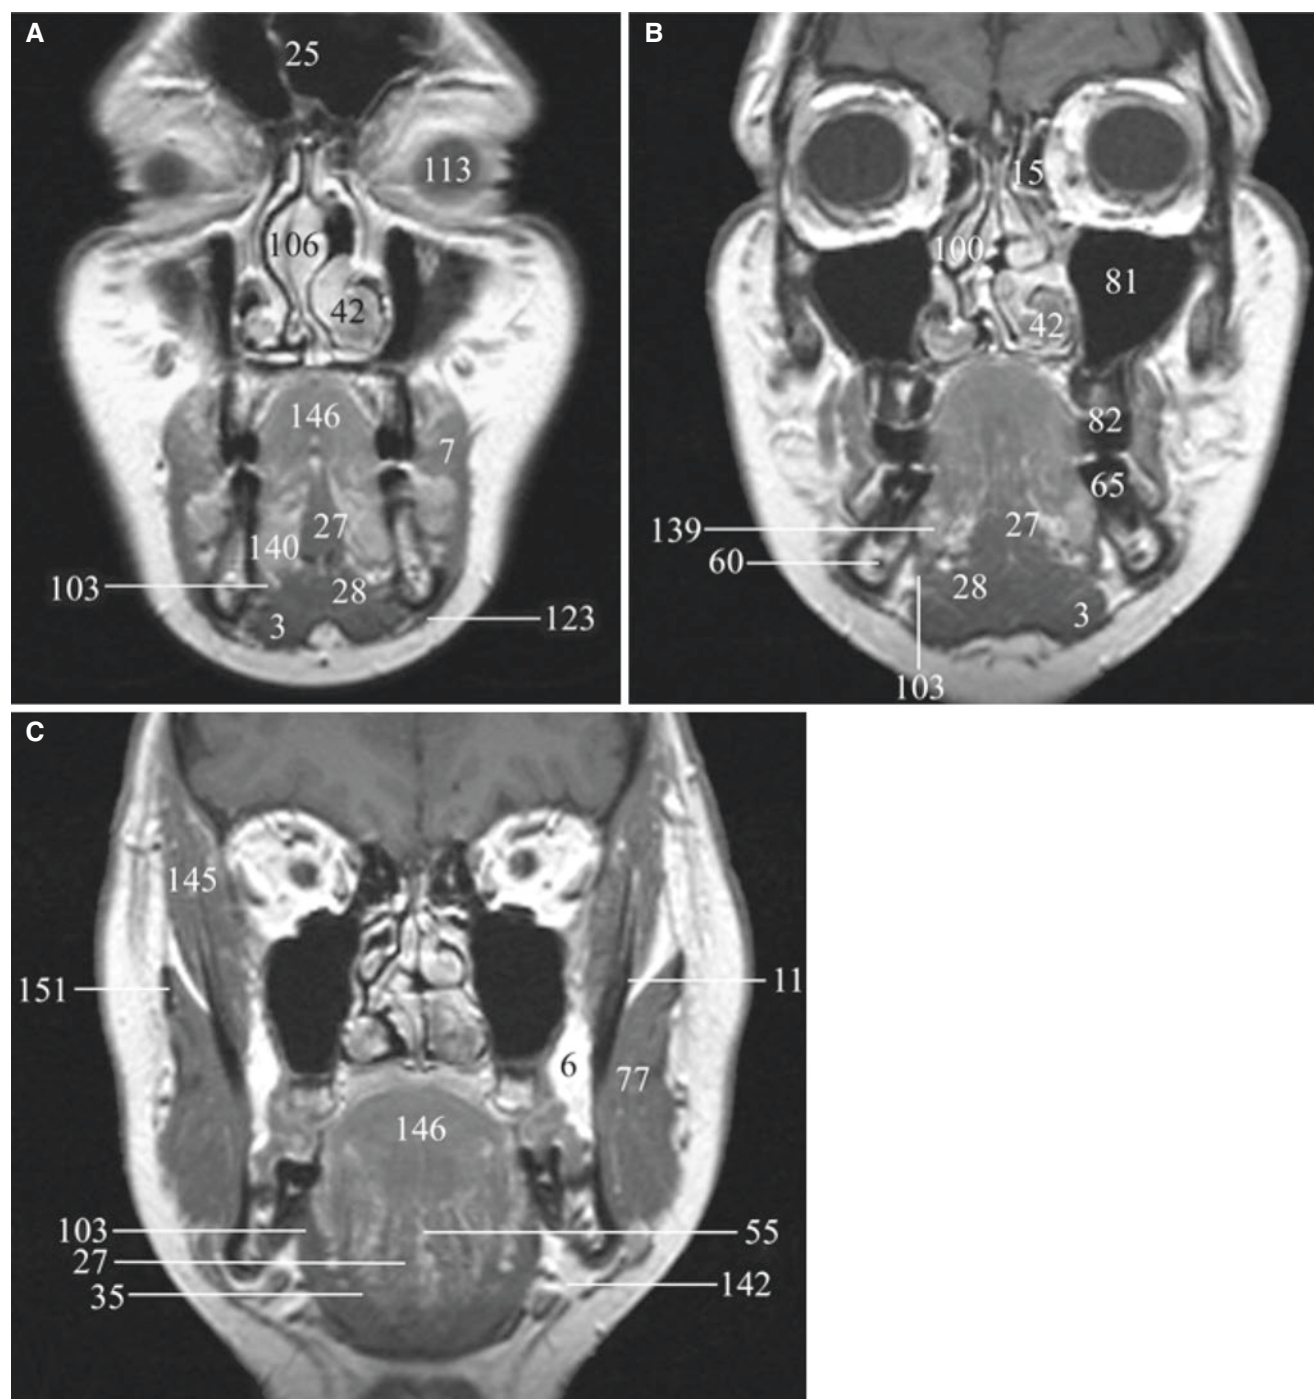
Normal anatomy of the face; coronal T1-weighted post-Gd MR images from anterior (A) to posterior (C)
